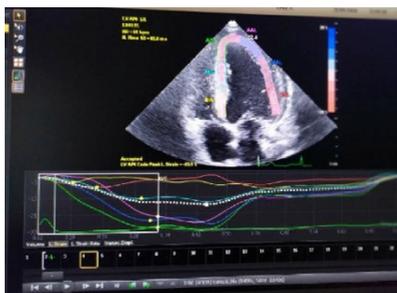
Apical 4C strain calculation.
